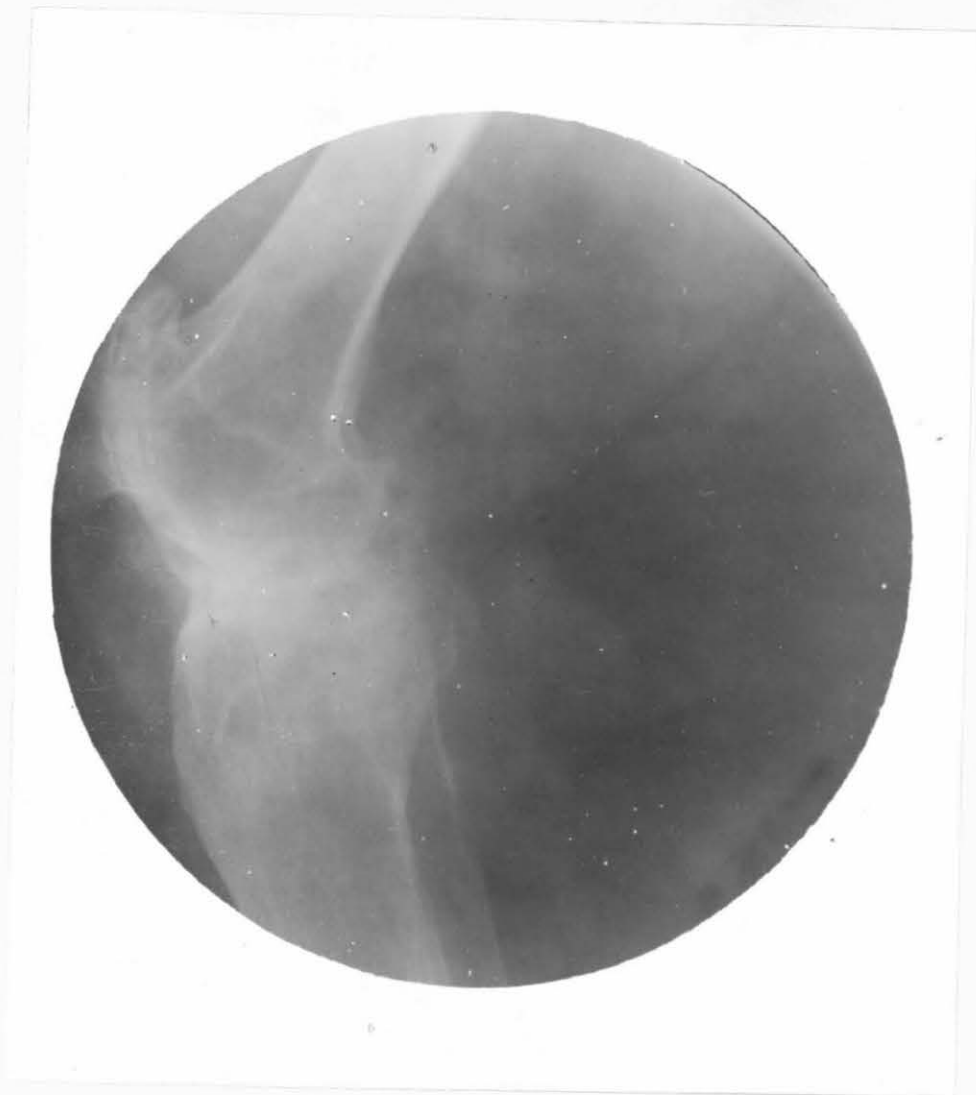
(Case A371241). Roentgenogram of Proliferative Arthritis of the left knee joint shown in Figure 1. Lateral view.
